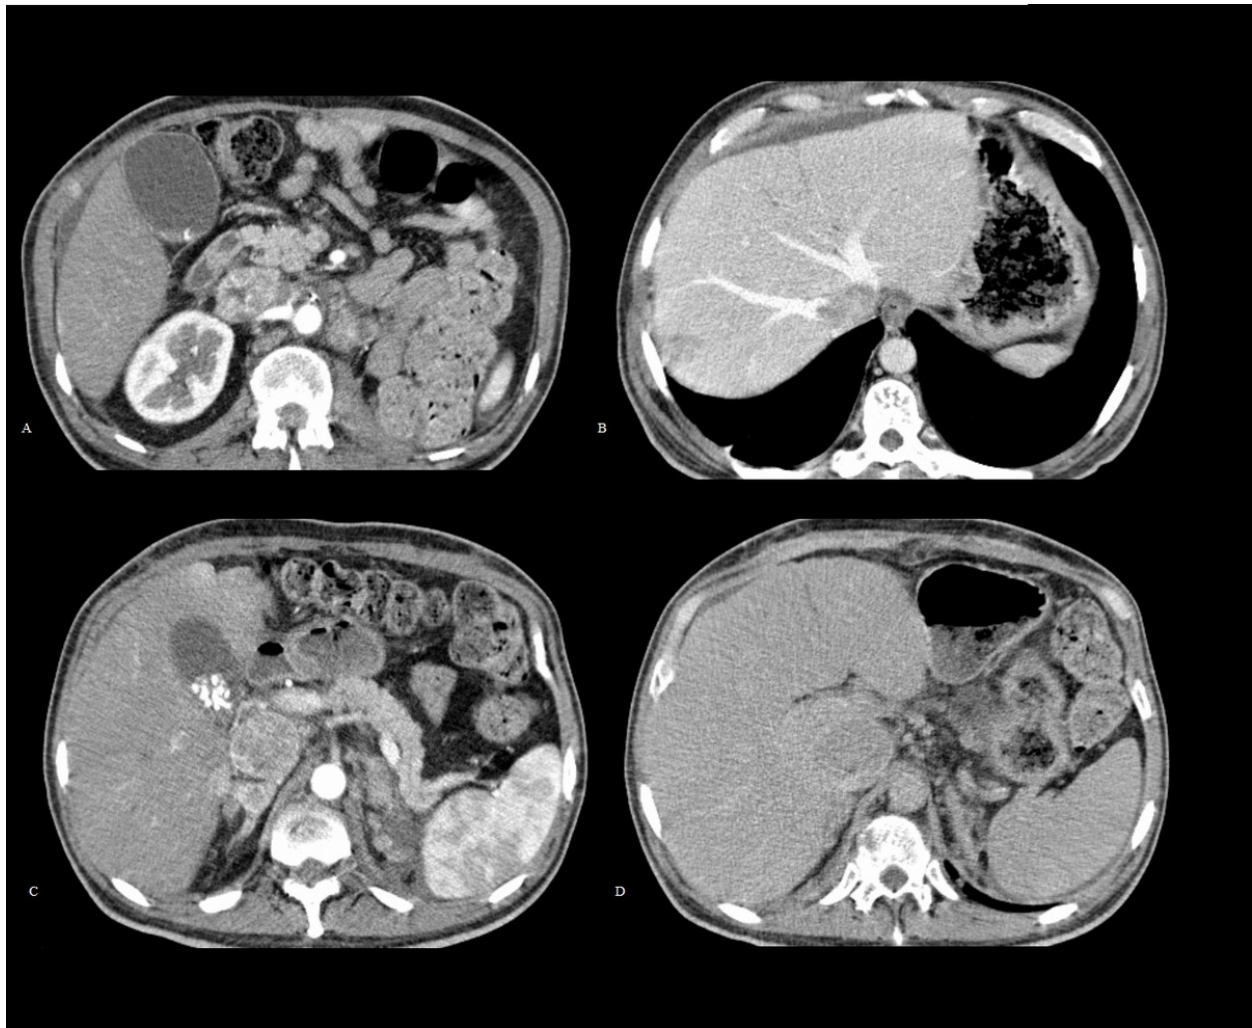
Malignant IVC thrombosis: Axial enhanced computed tomography (arterial phase (A,B), venous phase (C) and delayed venous phase (D)) show a large thrombus in the IVC, with heterogeneous arterial enhancement with wash-out on venous and delayed venous phase. This patient had a left radical nephrectomy for a renal cell carcinoma.
